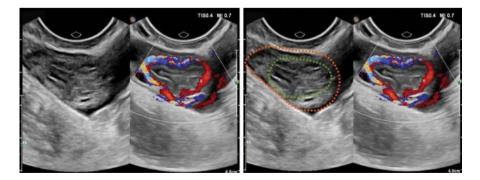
Left: Gray-scale ultrasound shows a late-stage corpus luteum cyst, exhibiting internal solid, heterogeneous, and slightly hyperechoic patterns that are poorly demarcated from the surrounding ovarian tissue. Right: Color Doppler ultrasound shows peripheral circumferential blood flow signals in the cyst wall. The ovary is circled in orange; the late-stage corpus luteum cyst is circled in green
